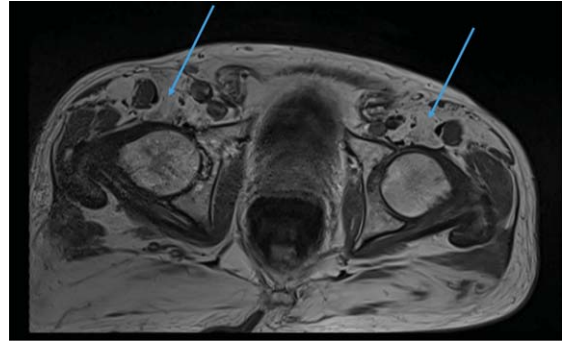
MRI of the pelvis. Complete fatty replacement of the psoas muscles (arrows).
